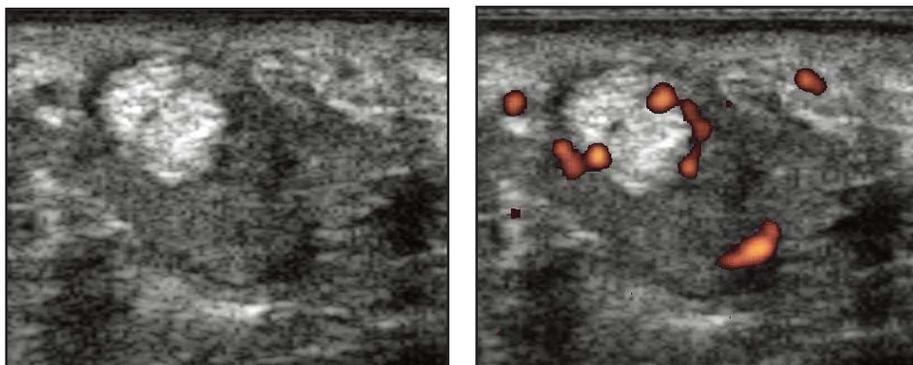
B-Mode And Doppler Transverse Images Of The Right 3rd Proximal Tendon Sheath Revealing Synovial Hypertrophy Within The Sheath With Associated Increase In Vascularity.
